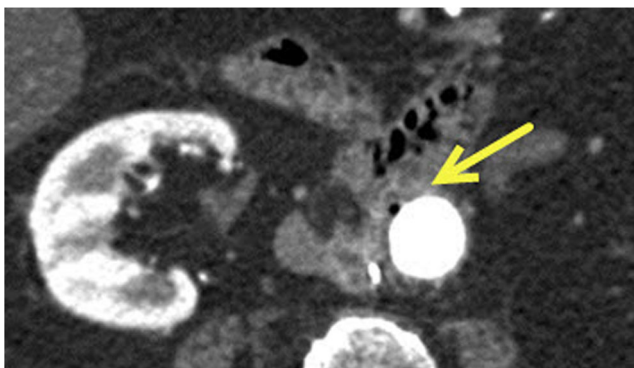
Transverse CT image showing effacement of the fat plane between the aorta and duodenum with air in the aortic wall (*arrow*), a classic appearance of an aortoenteric fistula
